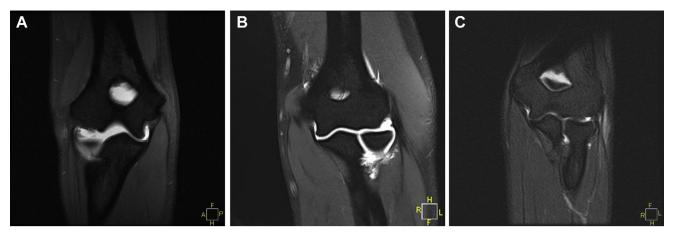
(A-C) MRI arthrogram images of the 3 patients showing disruption of the proximal insertion site of the ulnar collateral ligament.
